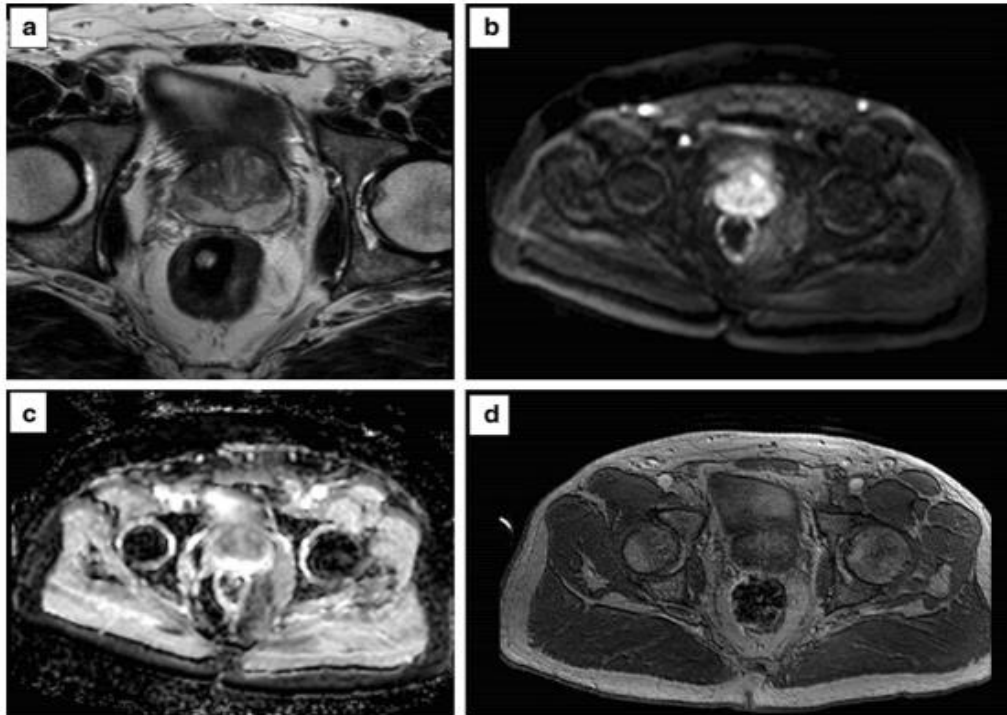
Axial T2w imaging(a) DWI with a b value of 150s/mm²(b), ADC map (c) and DCE acquisition(d) of a study that was given a PI-QUAL score of 1. All MR sequences are below the minimum standard of diagnostic quality as per PI-RADSV.2.1 technical recommendations. In particular, T2w imaging and DWI(a-c) show motion artefacts, no high b value has been acquired(b), the field of view is too large on DWI (21x35cm, in b, c) and on DCE sequences (21x33cm in d), and there is no fat suppression of DCE sequences (9)
